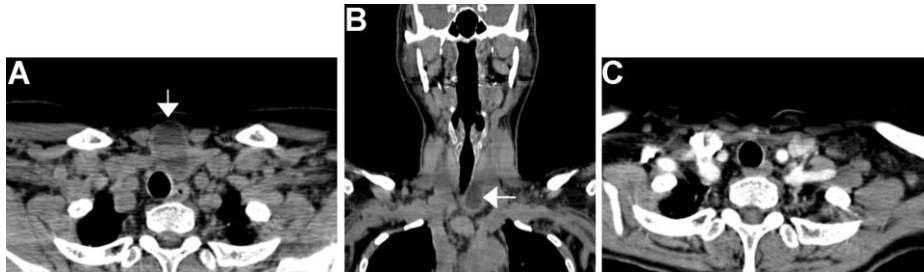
Pre-operative axial (A) and coronal (B) computed tomography views demonstrating a left paratracheal cystic lesion (white arrows). (C) Follow-up axial CT performed three months post excision showing the absence of the prior lymphocele.
